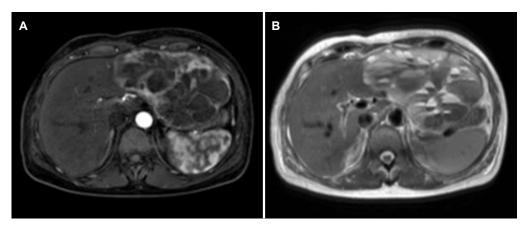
Liver magnetic resonance imaging findings. (A) Early (15 seconds) arterial phase. Non-smooth margined multiseptated mass with septal enhancement is found in hepatic segment II, III. (B) T2WI phase. Fluid level without evidence of blood is found in the cystic portion.
